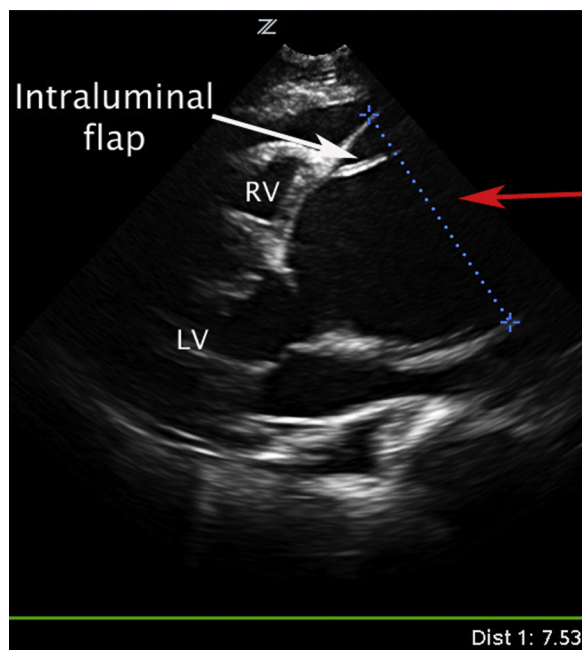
Parasternal long axis view of the heart showing a dilated aortic root (red arrow) measured at 7.53 cm (seen at right lower corner of image) with a visualized intraluminal flap. LV = left ventricle; RV = right ventricle.
